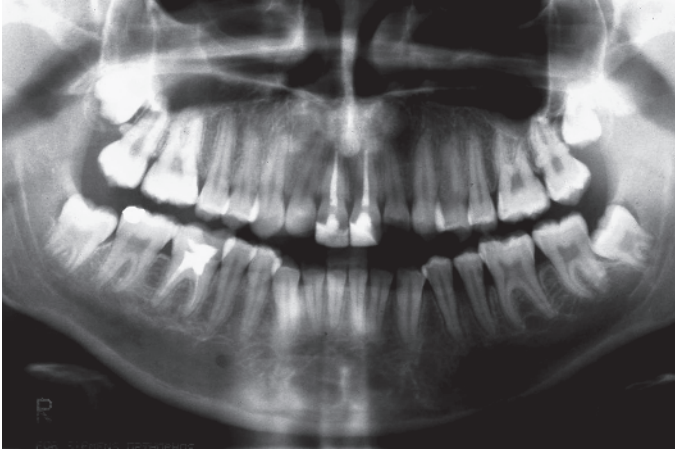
Orthopantomogram showing enamel pearls on upper right and left second molars. *Source:* Eickholz and Hausmann 1998.
